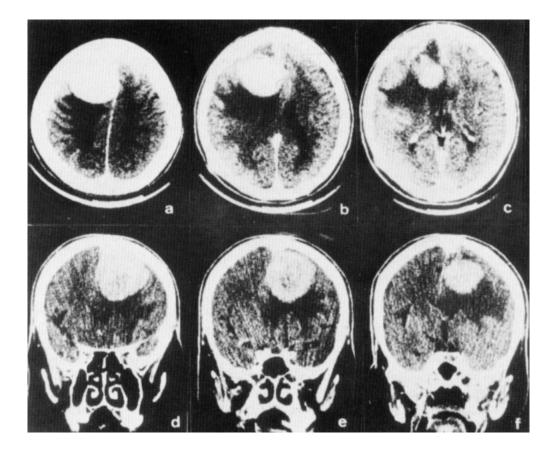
Infused computerized tomography (CT) of horizontal (a-c) and coronal (d-f) scans.
